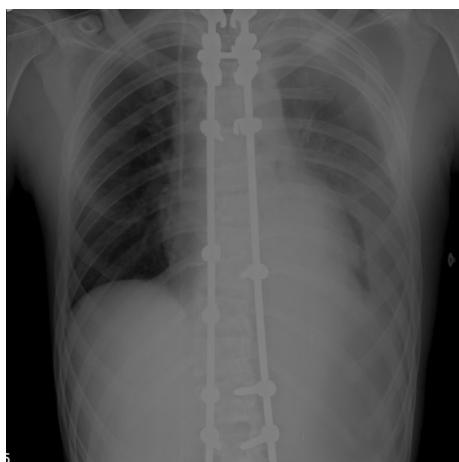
Chest X-ray after posterior spine fusion showing both sternoclavicular articulations in place
